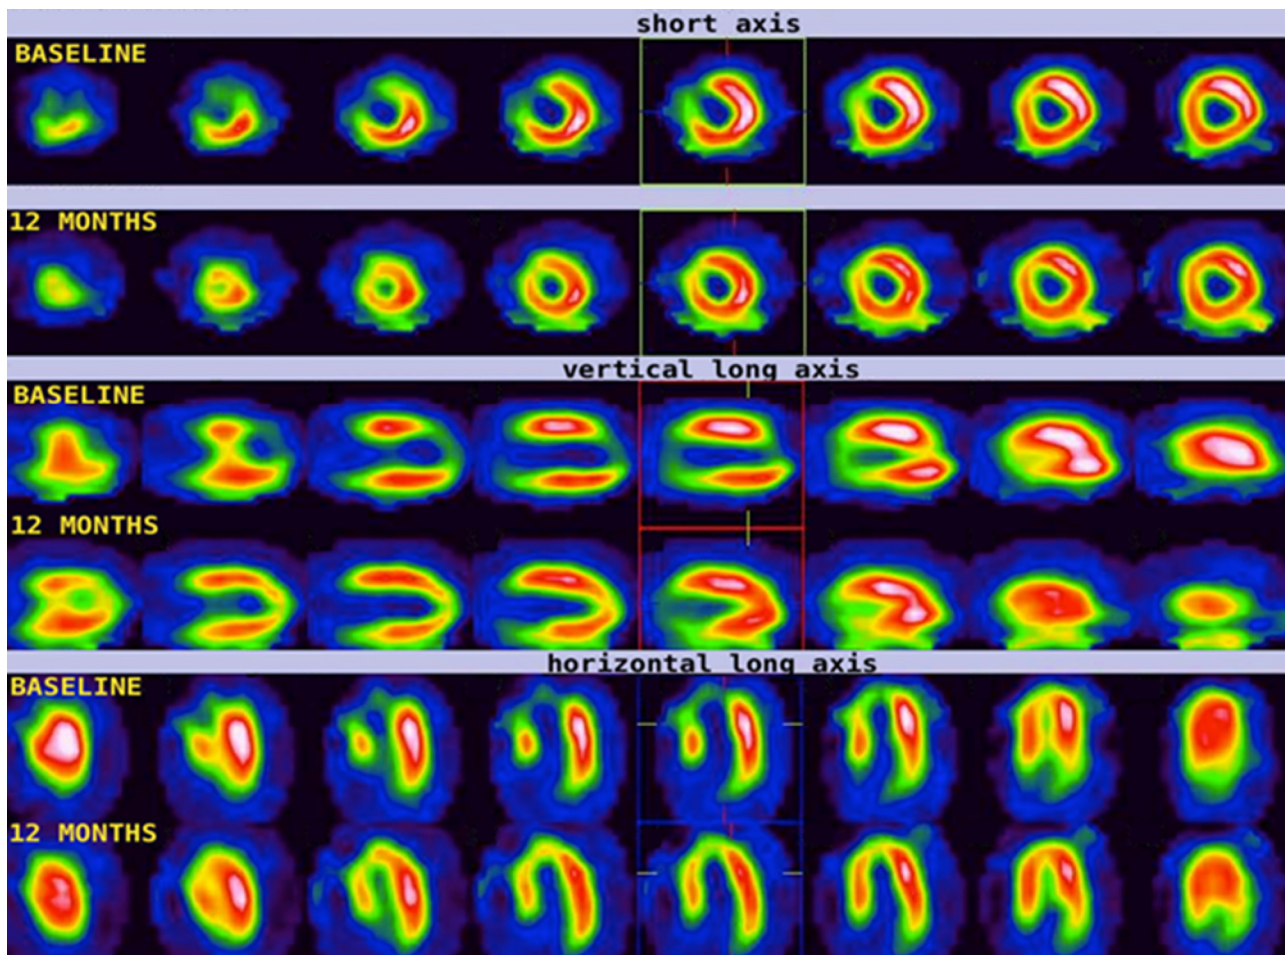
Multiple slices from apex to base of short-axis, vertical long-axis and horizontal long-axis images represent iodine 123 meta-iodobenzylguanidine (123I MIBG) distribution in left ventricle at baseline and 12-month follow-up in a patient with takotsubo cardiomyopathy who received α -lipoic acid (ALA). These images represent, at baseline and at 12-month follow-up, the assessment of myocardial 123I MIBG distribution in ALA patient at both subacute (baseline) and chronic phase (12 months). In the subacute phase, 123I-MIBG uptake was severely reduced in the apex and in the apical and mid segments of antero-septal left ventricle (LV) wall, whereas myocardial perfusion at rest was normal, showing only moderate apical contractile dysfunction. 123I-MIBG scintigraphy was performed at 12-month follow-up after the acute symptomatology. At follow-up images, there is a reduction of 123I-MIBG defect, with greater increases of the tracer uptake predominantly in the apical, anterior, and apical-septal LV segments.
